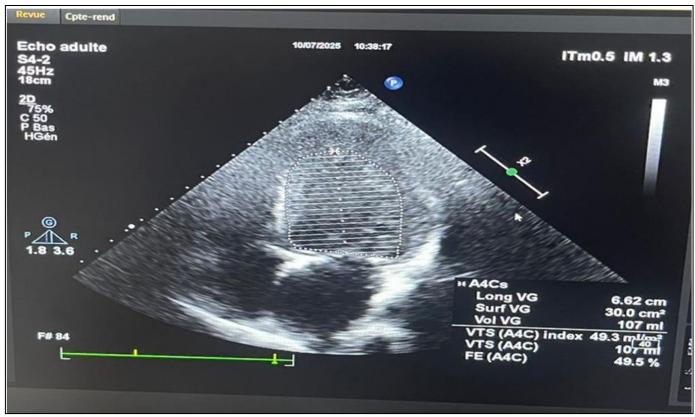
Echocardiogram Showing Improved Left Ventricular Ejection Fraction.
